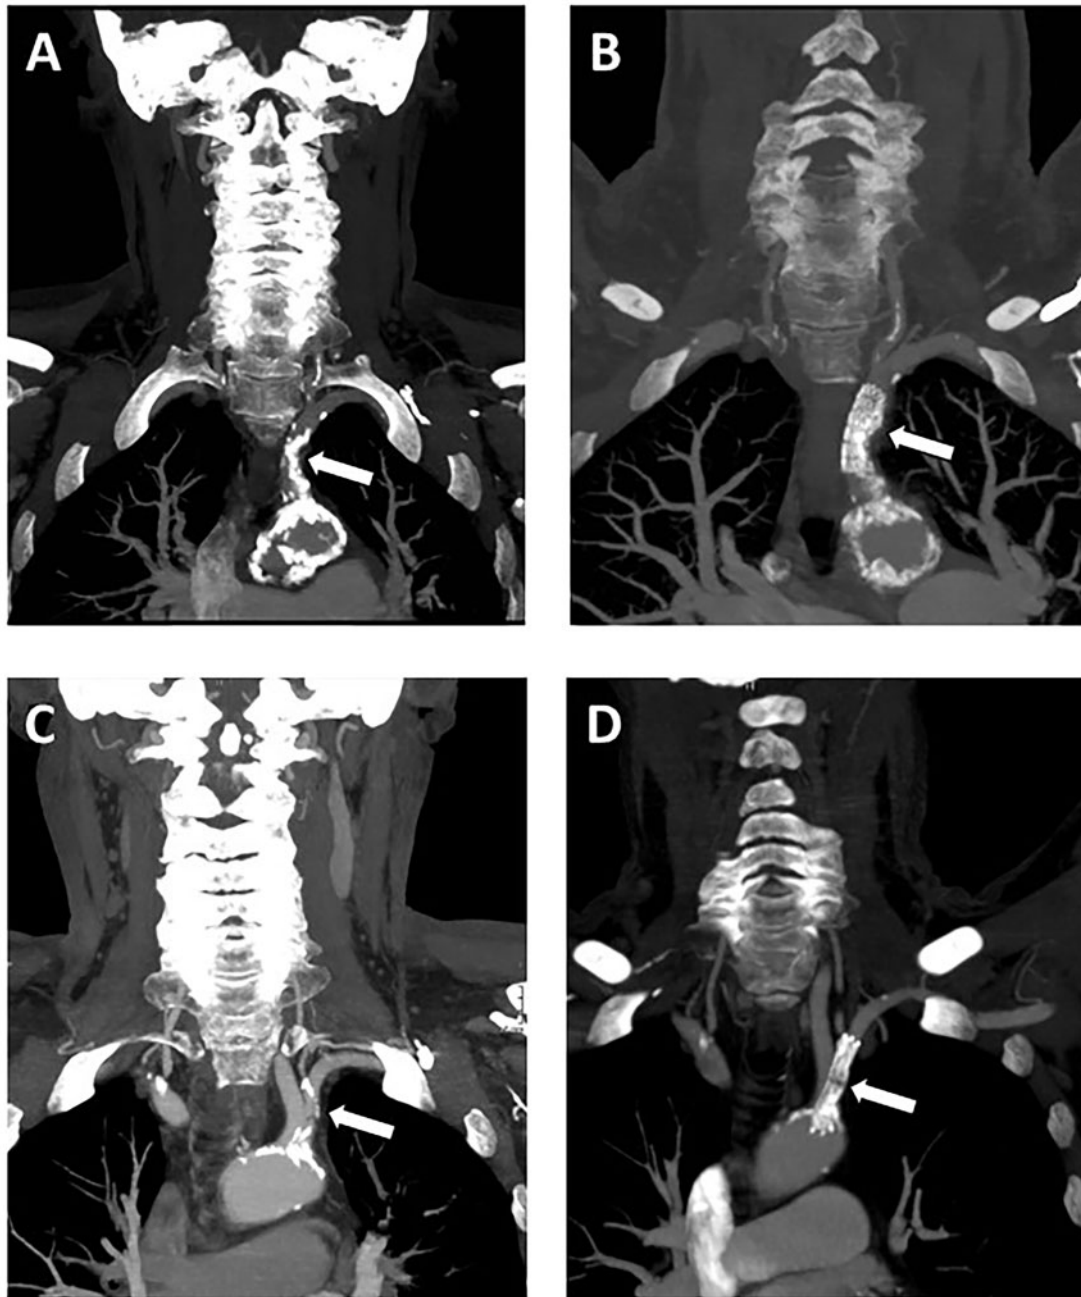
Chest computed tomography angiogram of Patient 1 (A and B) and Patient 3 (C and D). A and C show severe left subclavian artery stenosis before endovascular intervention, while B and D show adequate stent implantation result in both patients (arrows).
